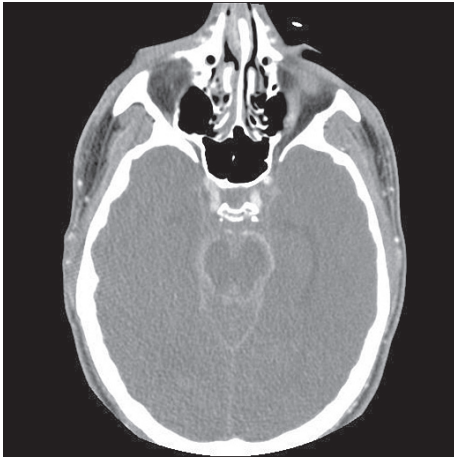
brain CT scan: a massive brain haemorrhage, with the discharge of the contrast liquid from left vertebral artery with very abundant cerebral aedema.
